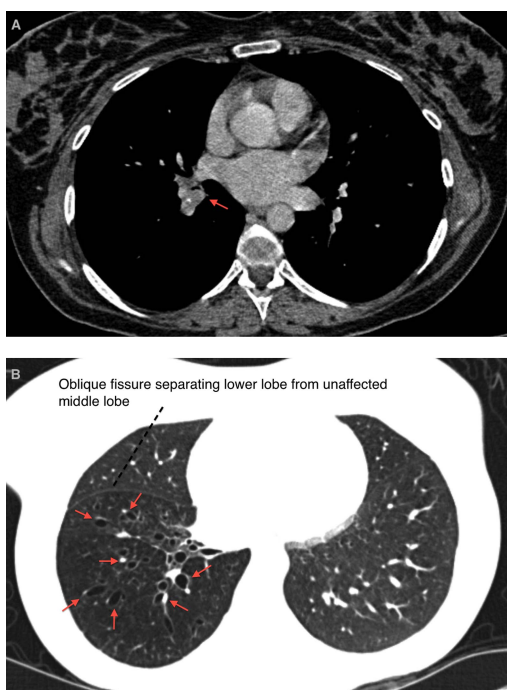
(A) CT scan showing a partially calcified lesion causing obstruction to the lumen of the right lower lobe bronchus. (B) CT scan showing distal bronchiectasis.
